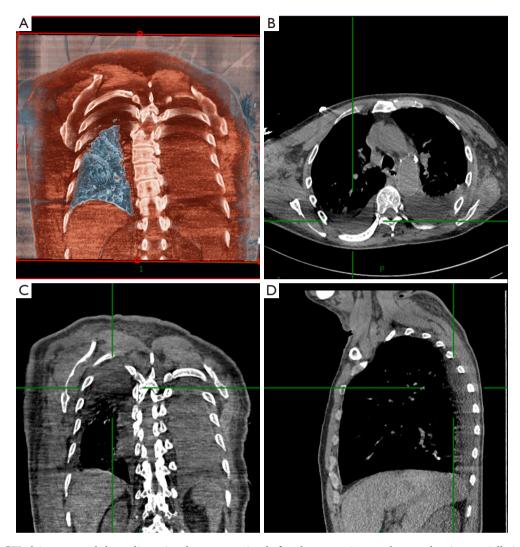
Lung CT plain scans and three-dimensional reconstruction before lung recruitment therapy showing partially inflated lungs and large dorsal consolidation. (A) Chest CT three-dimensional reconstruction (abdomen and lung structure rendering) in the coronal plane; (B) chest CT in the horizontal plane; (C) chest CT in the coronal plane; (D) chest CT in the sagittal plane.
